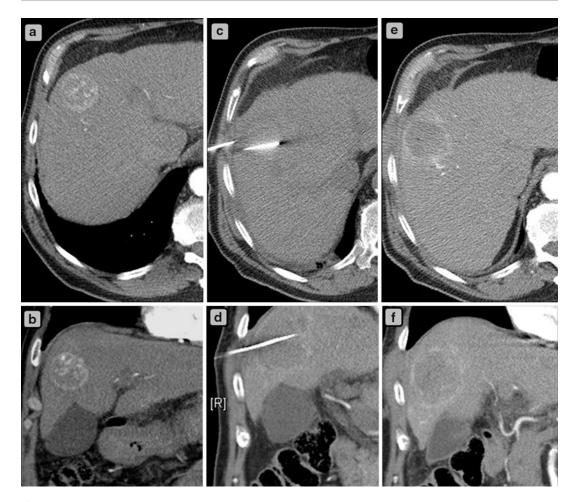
Axial and coronal contrast-enhanced CT images of (a, b), a hypervascular liver tumor prior to IRE ablation; (c, d) during the IRE monopolar probe
